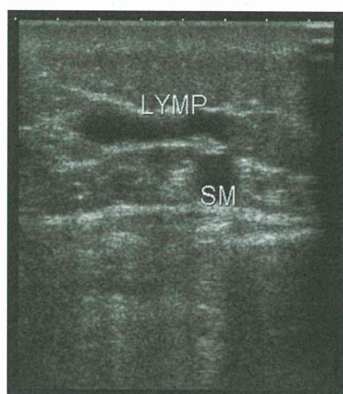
Ultrasonography image. Above the ankle, megalymphatics (LYMP) can be seen along the great saphenous vein (SM).
